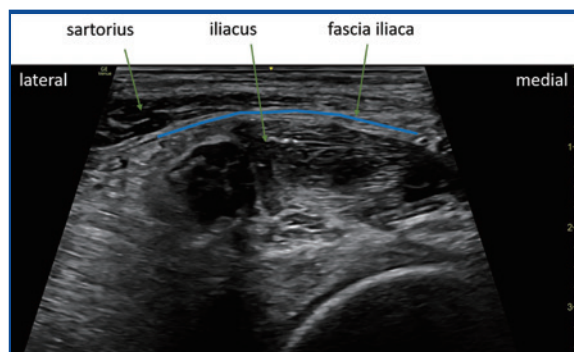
Ultrasound image of the fascia iliaca. The femoral vessels are located medial to the image (Ultrasound image and annotation by author)
